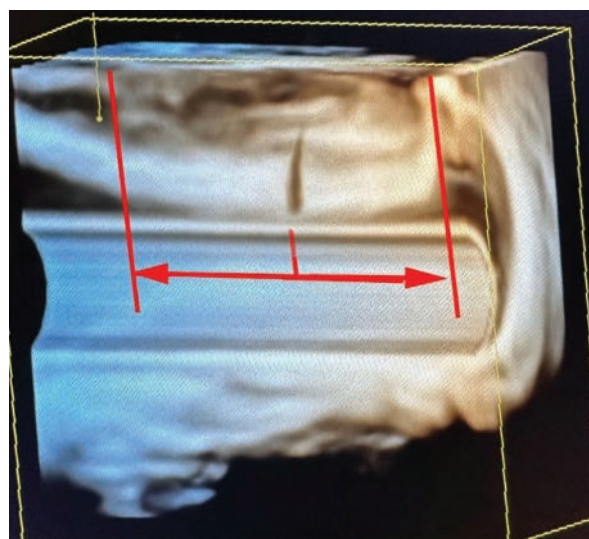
3D ultrasound picture of a fistula involving more than 50% of the external sphincter
